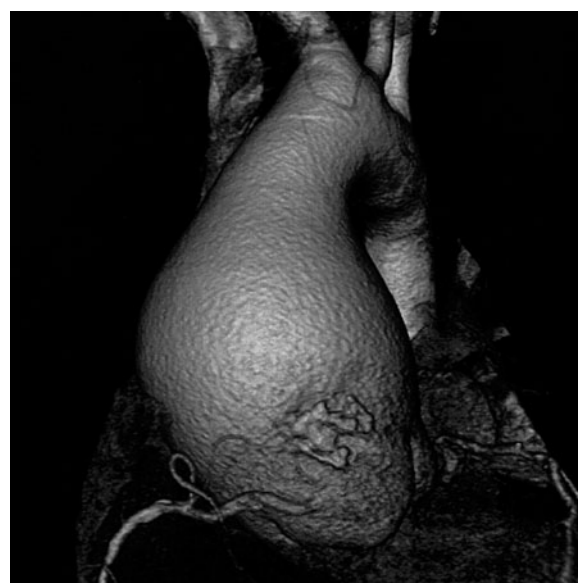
Aortic root aneurysm. This 64-slice CT reconstruction demonstrates a 7.9-cm diameter aneurysm in a 48-year-old male with aortic regurgitation through a three-leaflet aortic valve.
